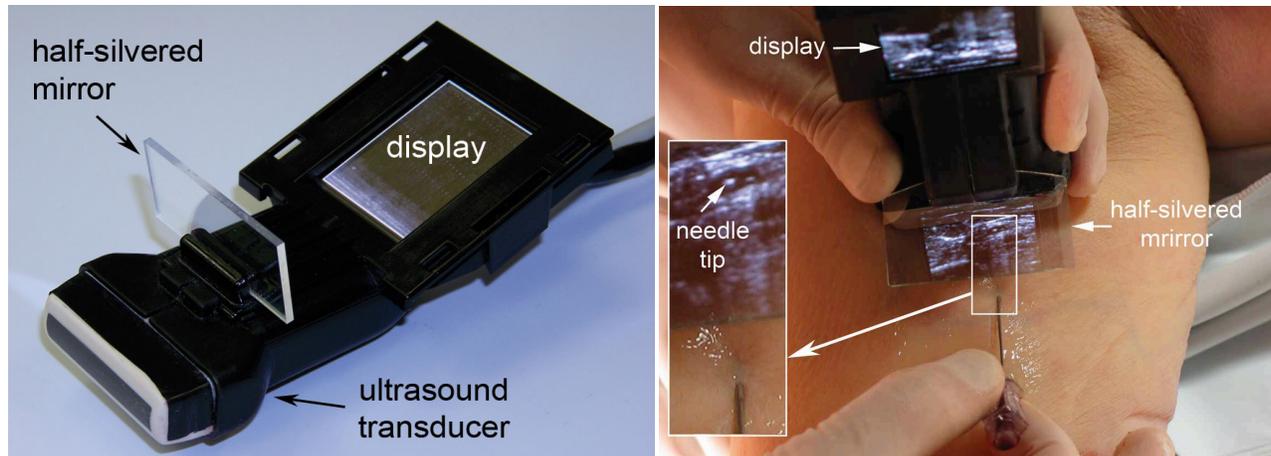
Sonic Flashlight device for viewing ultrasound in its actual location.
